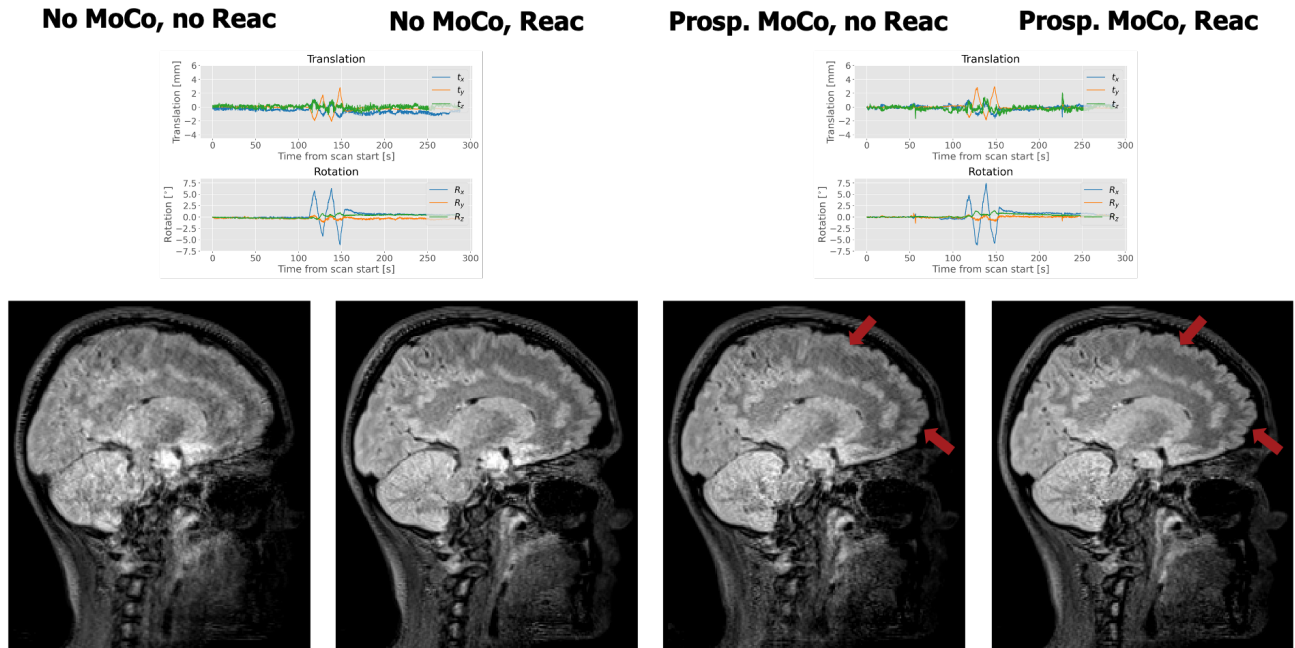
T<sub>2</sub> FLAIR image examples with nodding motion, comparing the reconstructed scans without and with reacquired slices for acquisitions without and with pMC. The improvement due to reacquisition, i.e. reduction of blurring and contrast enhancement, is clearly visible for the scans without MoCo. For those with pMC I marked areas with red arrows, where blurring and / or ringing was decreased in the scan with reacquisition. The corresponding motion curves are shown above the two respective images. All images shown were registered to the still, uncorrected scan.
